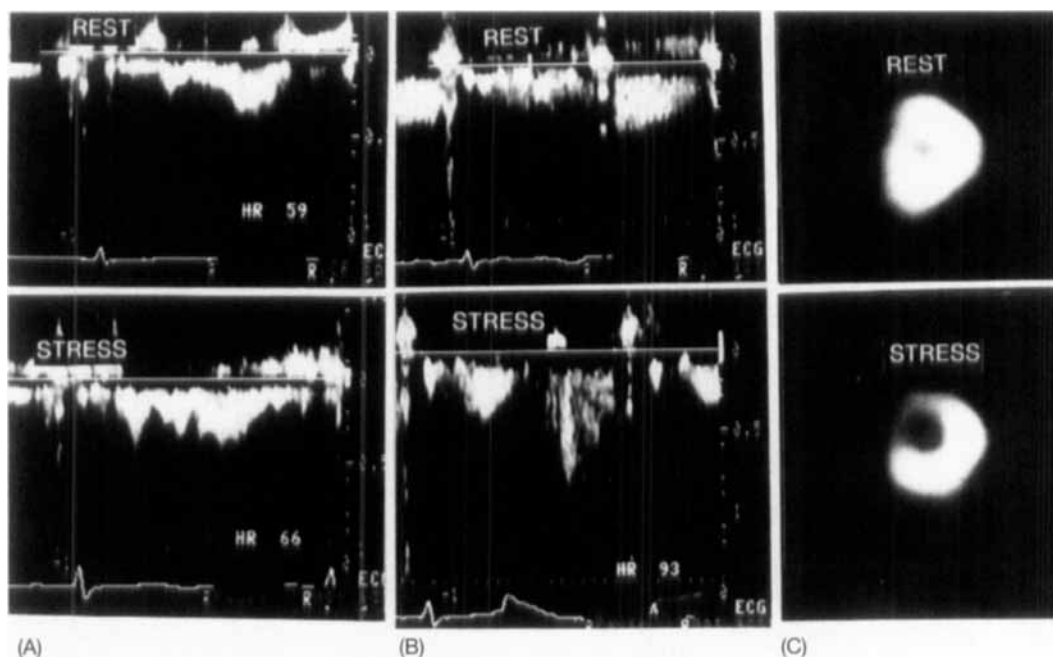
Patient with 86% area stenosis of the proximal left anterior descending (LAD) artery. (A) Transesophageal Doppler flow velocity recording in the coronary sinus at baseline and after dipyridamole resulting in a coronary flow reserve of 1.3. (B) Transesophageal Doppler flow velocity recording in the proximal LAD at baseline and after dipyridamole resulting in a coronary flow reserve of 1.8. (C) Short-axis adenosine stress/redistribution tomograms at the midventricular level demonstrating a reversible perfusion defect.
